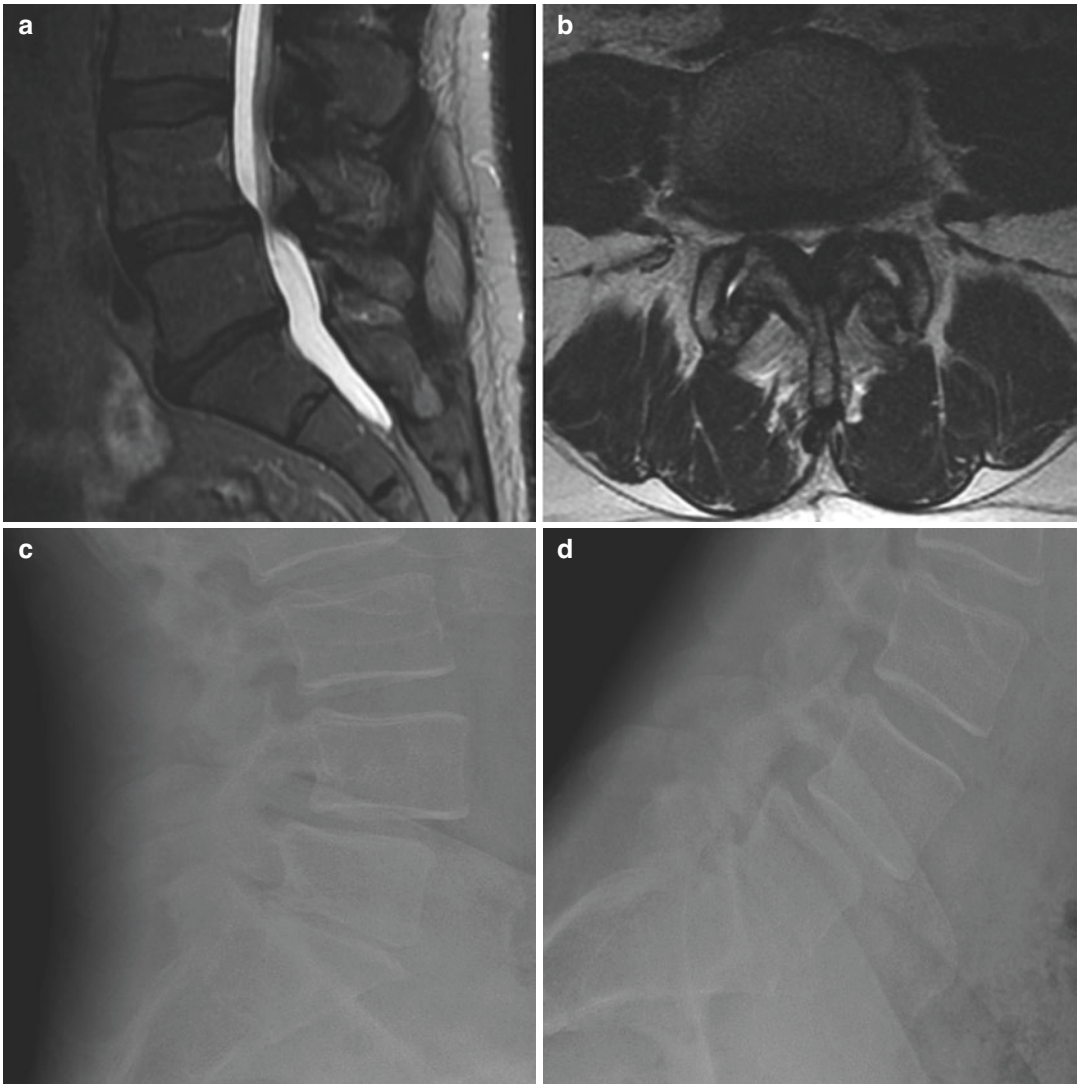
Preoperative images of the lumbosacral spine. Sagittal (a) and axial (b) T2 MRI showing central and lateral recess stenosis at L4-5. Extension (c) and flexion (d) X-rays demonstrate a mobilize spondylolisthesis at L4-5
